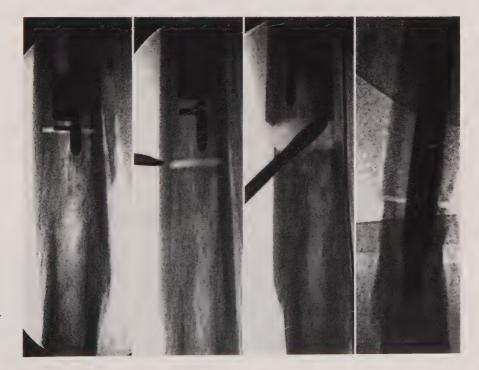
X-ray control of the incomplete osteotomy. Completion of the osteotomy with a chisel
